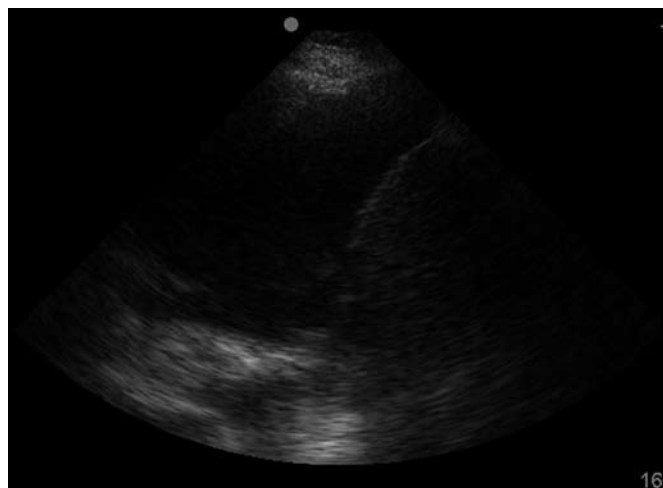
Transthoracic ultrasound being performed with patient in MT position to localize an insertion site for the thoracoscope.
